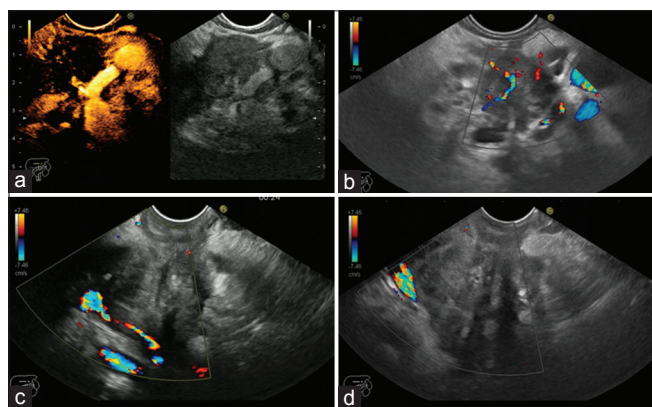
Vascular involvement in locally advanced pancreatic cancer. (a) Splenic artery encasement – contrast enhancement endoscopic ultrasound; (b) Hepatic artery encasement – color Doppler endoscopic ultrasound; (c) Celiac trunk invasion – color Doppler endoscopic ultrasound; (d) Portal vein invasion – color Doppler endoscopic ultrasound
